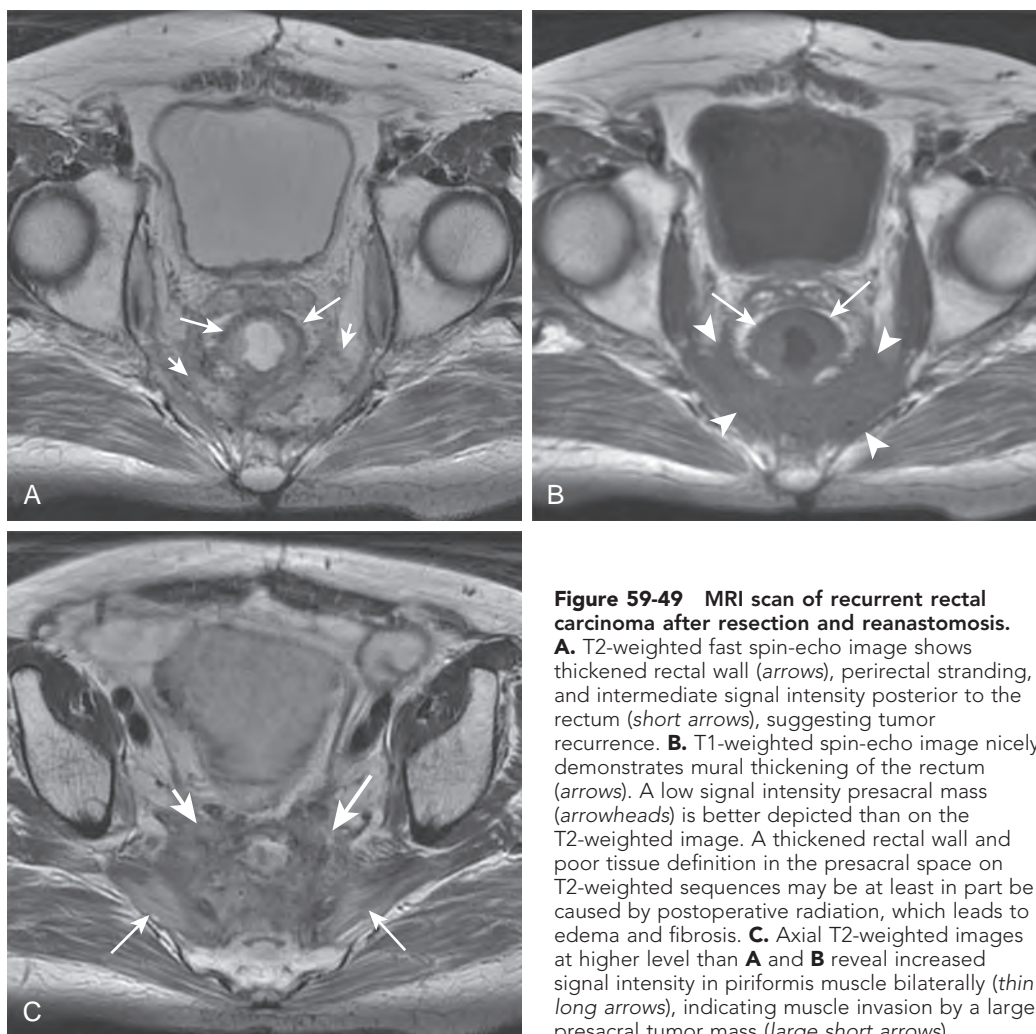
MRI scan of recurrent rectal carcinoma after resection and reanastomosis. A. T2-weighted fast spin-echo image shows thickened rectal wall (*arrows*), perirectal stranding, and intermediate signal intensity posterior to the rectum (*short arrows*), suggesting tumor recurrence. B. T1-weighted spin-echo image nicely demonstrates mural thickening of the rectum (*arrows*). A low signal intensity presacral mass (*arrowheads*) is better depicted than on the T2-weighted image. A thickened rectal wall and poor tissue definition in the presacral space on T2-weighted sequences may be at least in part be caused by postoperative radiation, which leads to edema and fibrosis. C. Axial T2-weighted images at higher level than A and B reveal increased signal intensity in piriformis muscle bilaterally (*thin long arrows*), indicating muscle invasion by a large presacral tumor mass (*large short arrows*).
